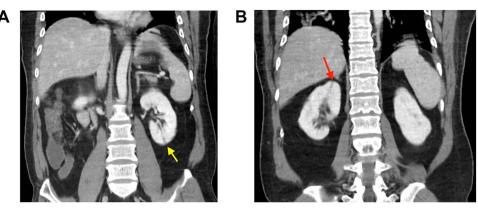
(a) Linear wedge-shaped infarct in left kidney (yellow arrow) on contrast enhanced CT. (b) Linear wedge-shaped infarct in right kidney (red arrow) on contrast enhanced CT.
